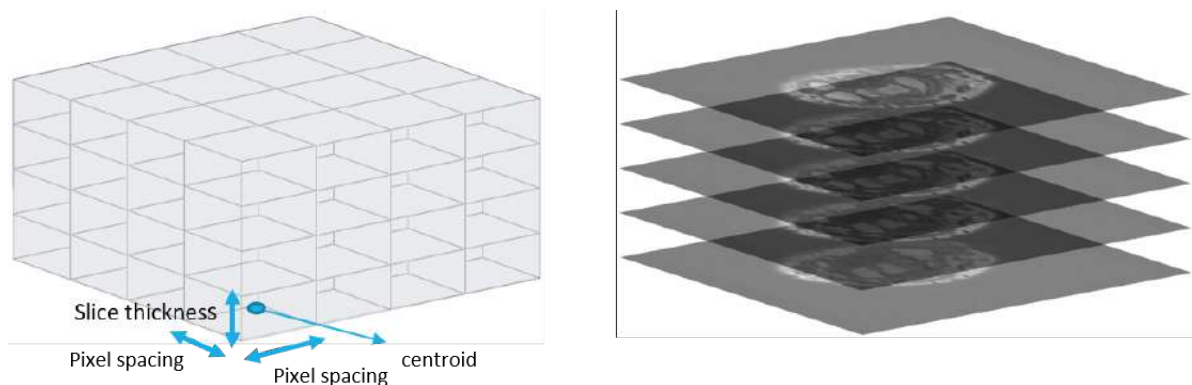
Analogy between the regular 3D grid describing the volume and the 2D stack of slices composing the volume MRI.
